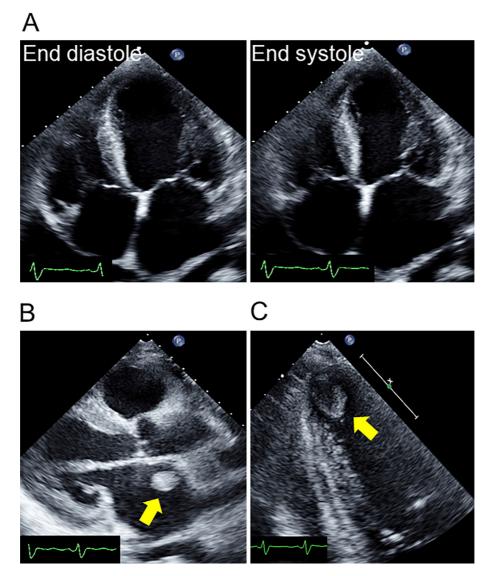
(A) Apical four-chamber echocardiographic view at end diastole (left) and end systole (right) at admission showed a mildly enlarged left ventricle (left ventricular end-diastolic diameter: 57 mm), left ventricular hypertrophy (left ventricular mass index: 136 g/m²), and diffuse severe hypokinesis of wall motion (ejection fraction: 24%). (B) Parasternal long-axis view showing thrombus formation (yellow arrow) in the left atrium. (C) Zoomed image of the apical four-chamber view focusing on the left ventricular apical thrombus (yellow arrow).
